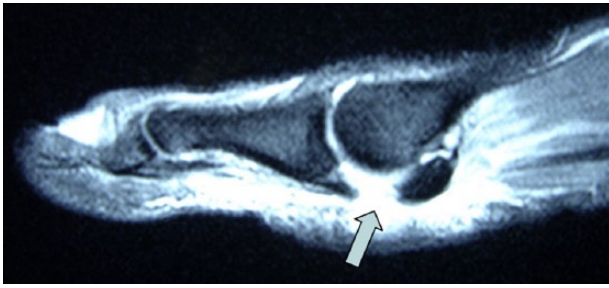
A sagittal T2 MR image demonstrating a grade 3 turf toe injury.
